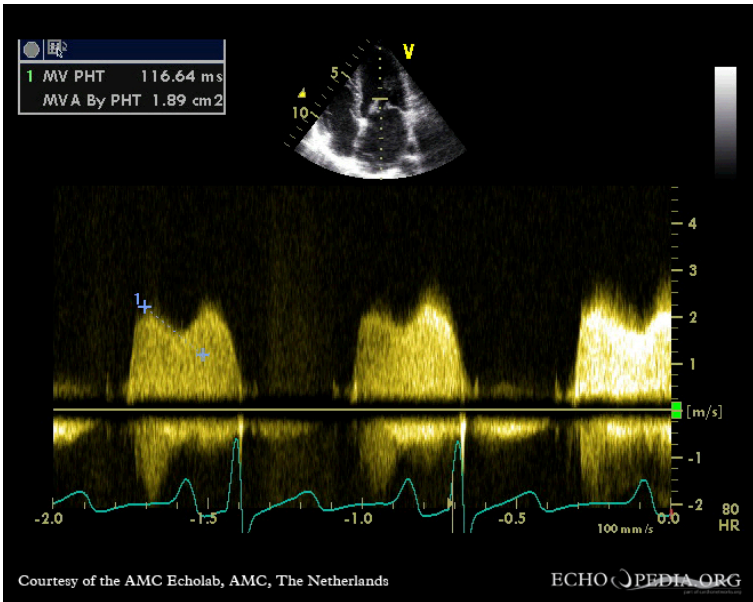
Echocardiogram showing severe mitral valve stenosis. [Severe mitral valve stenosis E00615 \(CardioNetworks ECHOPedia\)](#) by CardioNetworks licensed under [CC BY-SA 3.0](#)
